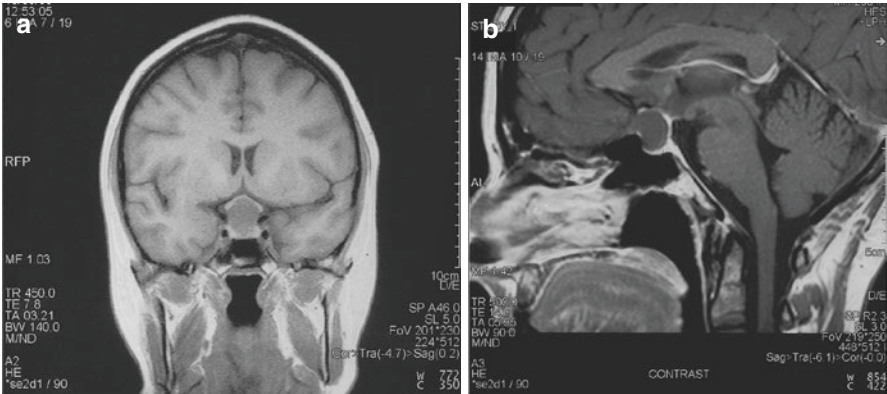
(a) T1 weighted coronal MRI scan showing a cyst arising from the pituitary fossa and extending upwards to elevate the chiasm in the midline; (b) T1 weighted sagittal MRI following administration of contrast showing uptake of contrast agent within the wall of the cyst but not within
